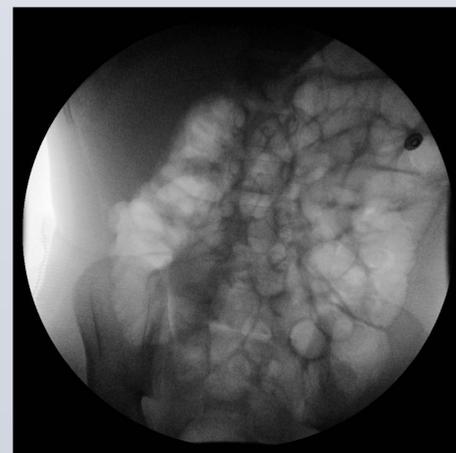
Ileocolic intussusception on ultrasound without concerning features. Fluoroscopic spot film demonstrates successful therapeutic air enema with reflux of air into the small bowel.
